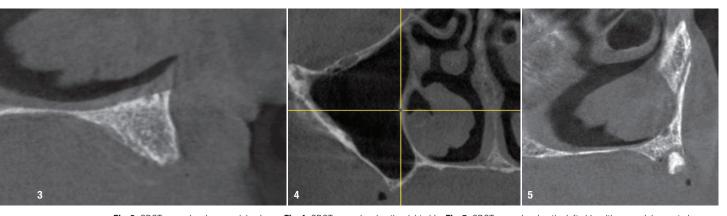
CBCT scan showing remaining bone. Fig. 4: CBCT scan showing the right side. Fig. 5: CBCT scan showing the left side with a remaining root piece.
